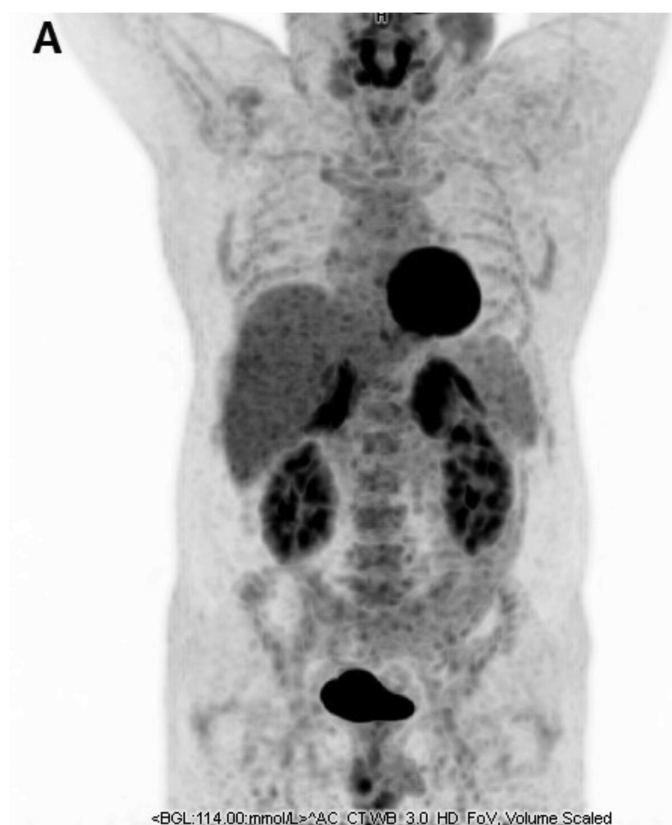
18F-FDG PET/CT image of congenital adrenal hyperplasia and testicular adrenal rest tumors
